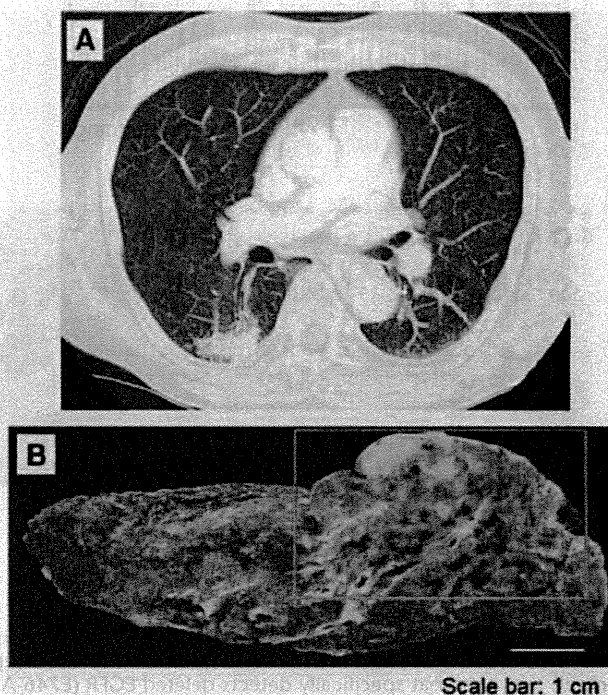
A, Computed tomography showing an irregular nodule in the right lower lobe of lung. B, Cut sections of the tumor are seen by the encircled part.
